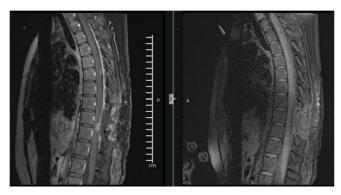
MRI thoracic spine with contrast T1 without contrast on the right and T1 with contrast on the left sagittal cuts
